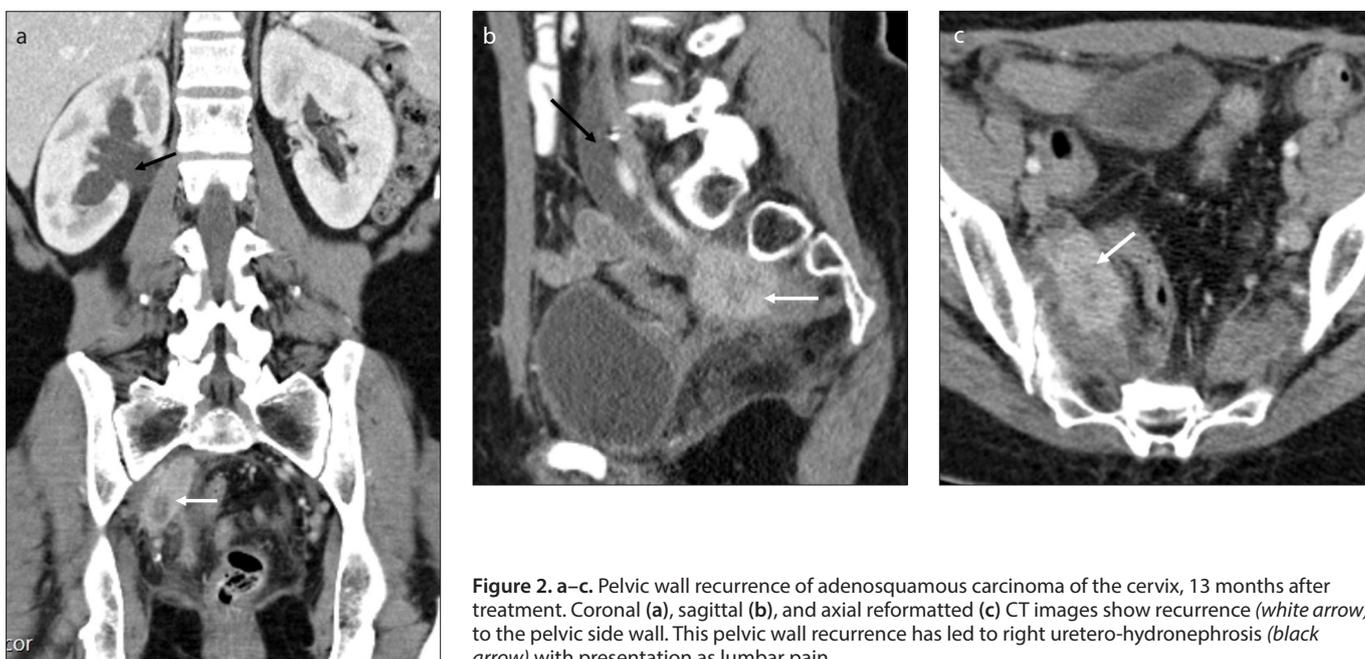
a–c. Pelvic wall recurrence of adenosquamous carcinoma of the cervix, 13 months after treatment. Coronal (a), sagittal (b), and axial reformatted (c) CT images show recurrence (white arrow) to the pelvic side wall. This pelvic wall recurrence has led to right uretero-hydronephrosis (black arrow) with presentation as lumbar pain.
